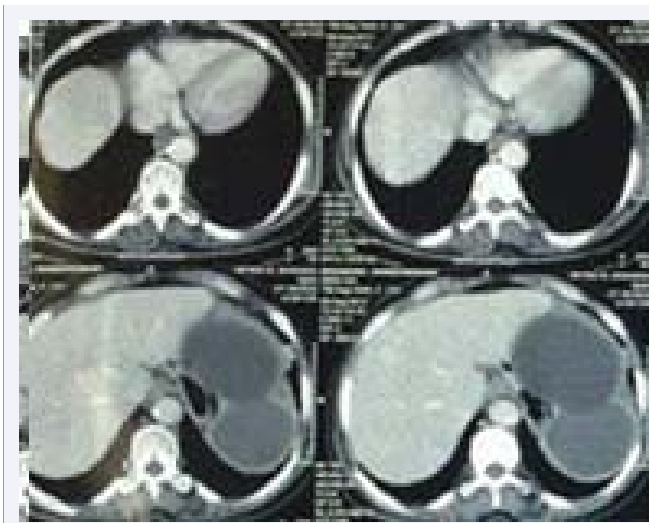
CT scan shows primary hydatid cyst of stomach.
